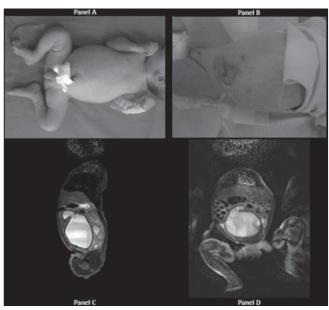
Panel A shows a large lower abdominal mass at birth (hydrometrocolpos). Panel B report reduction of abdominal mass after fluid drainage. Panel C and D report abdominal MRI (sag. and cor T2 w) shows large abdominal cystic mass communicating with endometrial lumen
